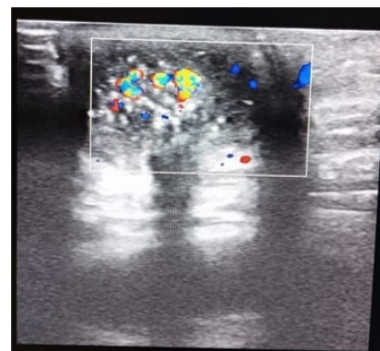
Doppler of umbilical swelling
